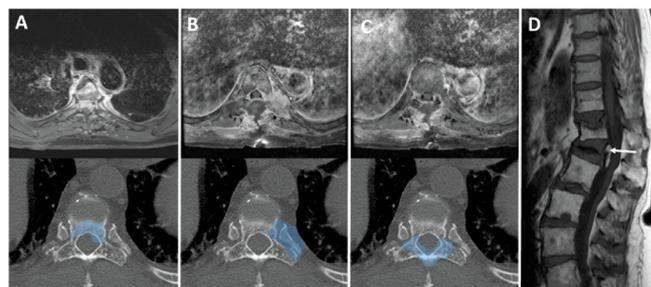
Spine metastases spreading. MRI (up)/axial CT scan (down) with anterior epiduritis and vertebral body metastases, (B) axial spine CT scan/MRI with pedicular and lateral metastases, (C) axial CT scan/MRI with posterior epiduritis and posterior arch metastases (D) sagittal T1-weighted MRI with L1 vertebral body collapse caused by metastases (white arrow).
